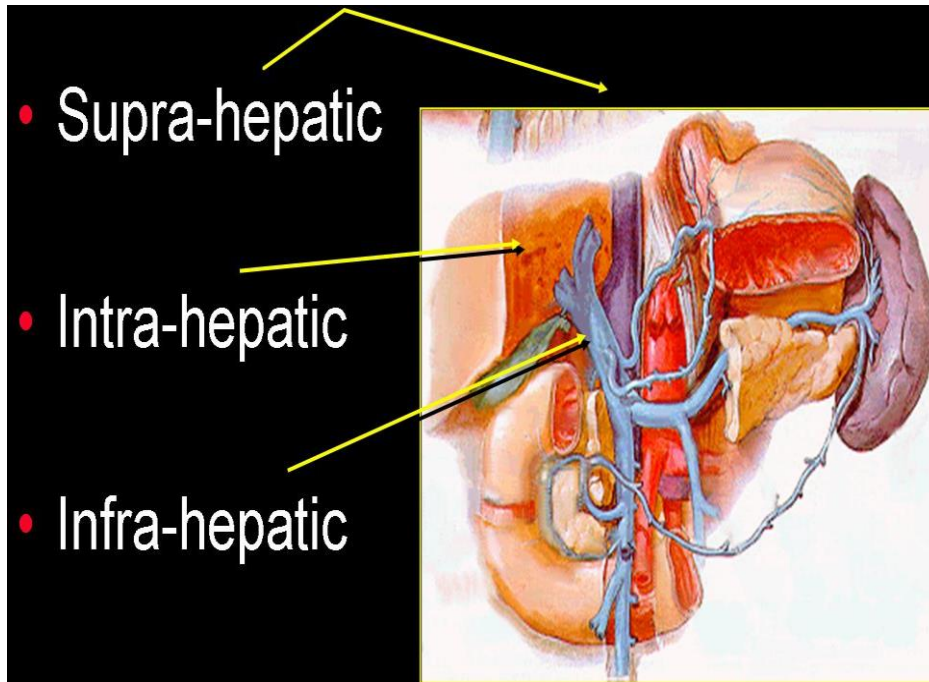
anterior view, pathological region of PHT anterior view (abdominal Doppler ultrasound 2013)
